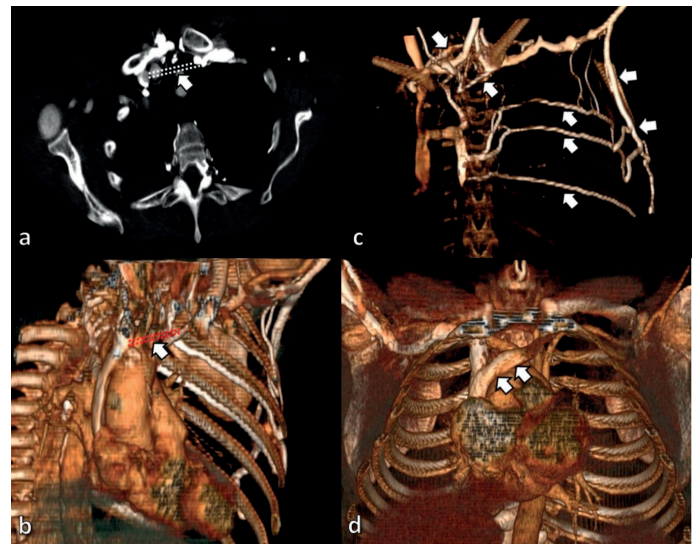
On axial contrast enhanced thorax CT and 3D reformat images (a, b) there is an interrupted course of left innominate vein (white and red dots). 3D reformat image (c) shows rich network of venous plexus (white arrows). The left subclavian vein continues as shunting by the help of the intercostal veins to azygos venous system and creating caval-caval anastomosis by the help of the superficial veins in same patient (c). 3D reformat image (d) shows normal left innominate vein (white arrows).
